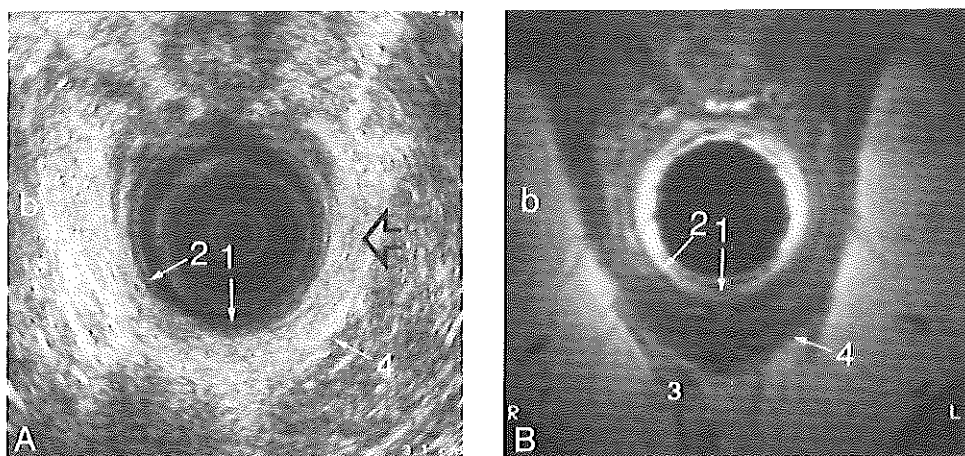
Axial images through the upper part of the puborectalis in a female (level indicated in Fig. 4.6). Endoanal sonography (A); endoanal MRI (B). With sonography, the hyperechoic puborectalis muscle (4) contains subtle hypoechoic fibres (open arrow). Sonographic configuration of the sling correlates well with the hypointense, well-demarcated puborectalis on MR image. Internal sphincter (1). Longitudinal layer (2). Ischioanal space (b).
